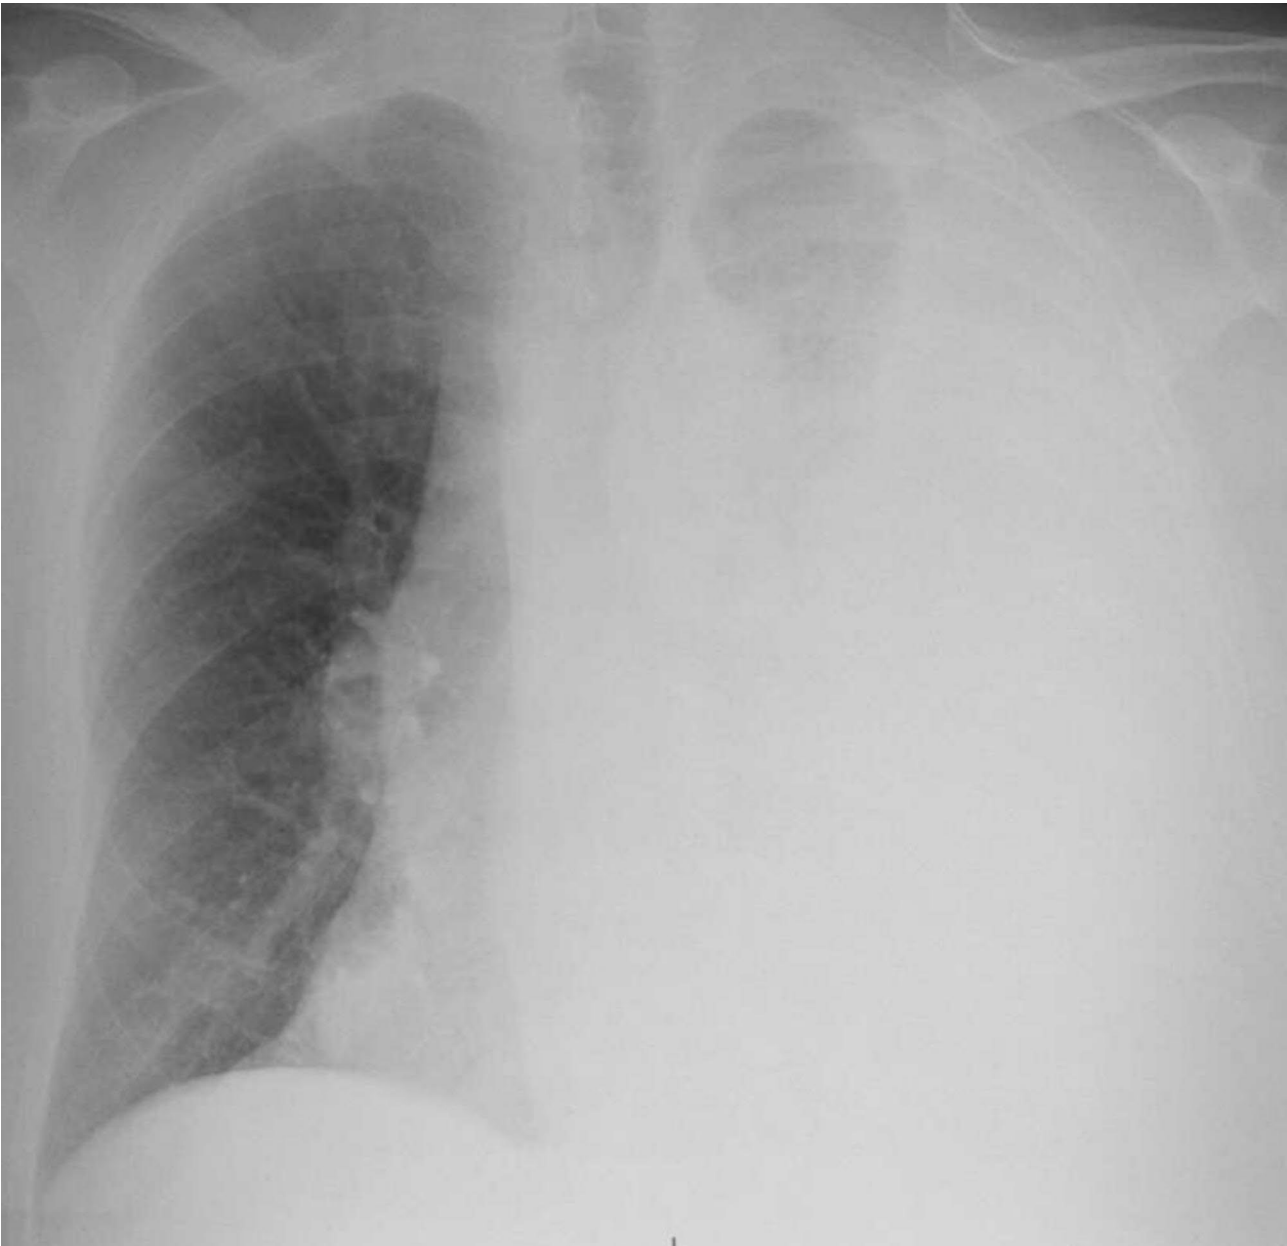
Chest X-ray showing opacification of left hemithorax with large left pleural effusion, mediastinal and hilar lymphadenopathy. There is minimal aeration of the left lung apex
